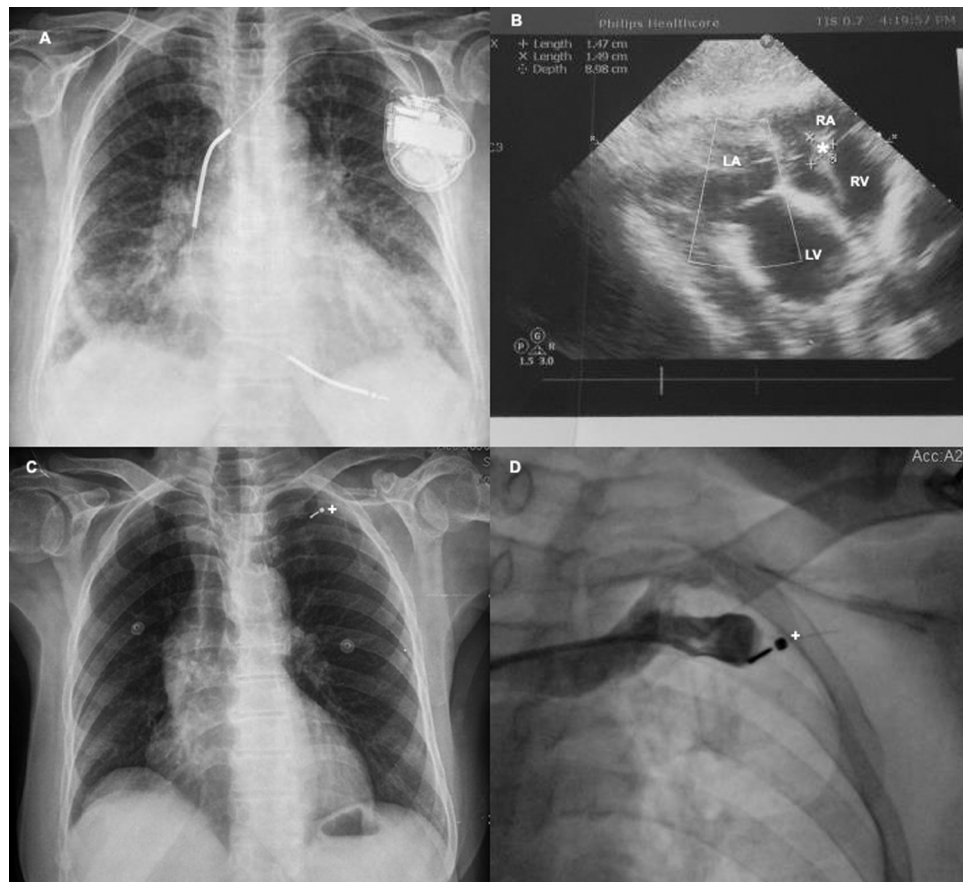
Chest X-ray image in the usual ICD (A), echocardiographic image of vegetation on the electrode (B), chest X-ray image in the regular electrode fragment (C), and left subclavian venography preventing passage opaque appearance as electrode fragment (D). RA, right atrium; RV, right ventricle; LA, the left atrium; LV, left ventricle; *, vegetation with thrombus; +, an electrode fragment.
